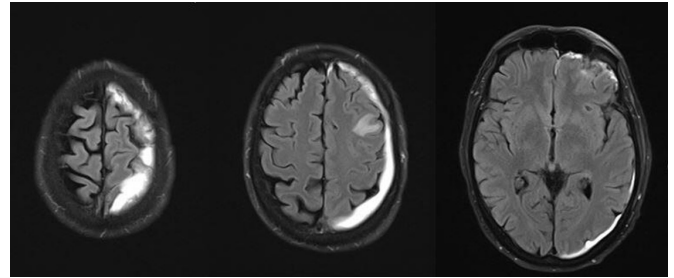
MRI of the head revealed a subacute subdural haematoma with possible evidence of encephalitis.
